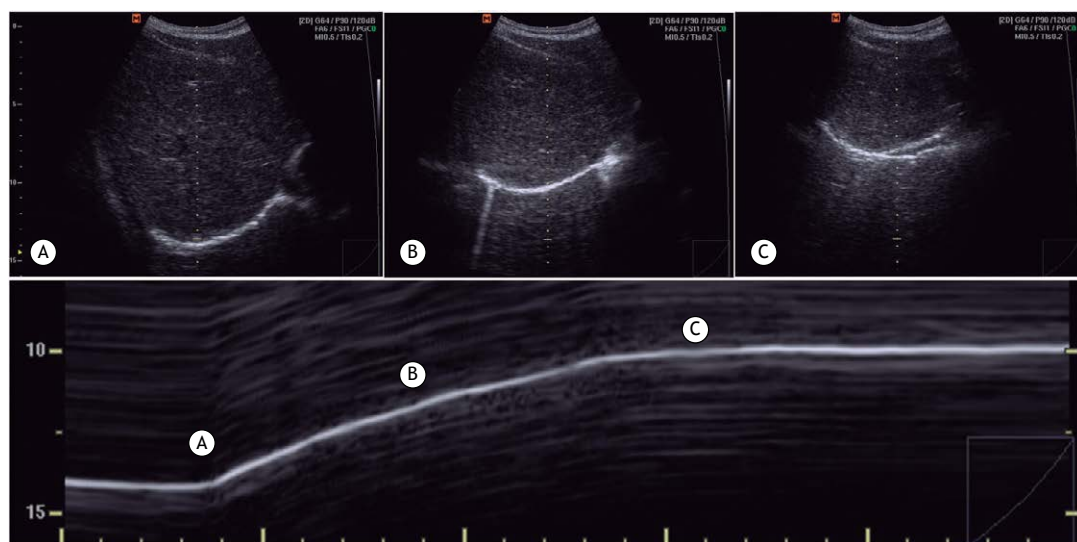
Assessment of diaphragmatic mobility by M-mode ultrasound, with the placement of markers for determining diaphragm displacement during the VC maneuver. A, B, and C indicate the beginning, middle, and end of the inspiratory cycle, respectively.
